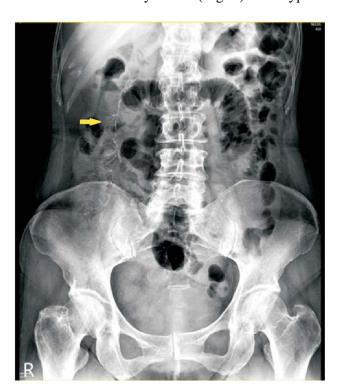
Abdominal plain X-ray film. Linear calcification was identified in right side of the abdomen (arrowed area).
